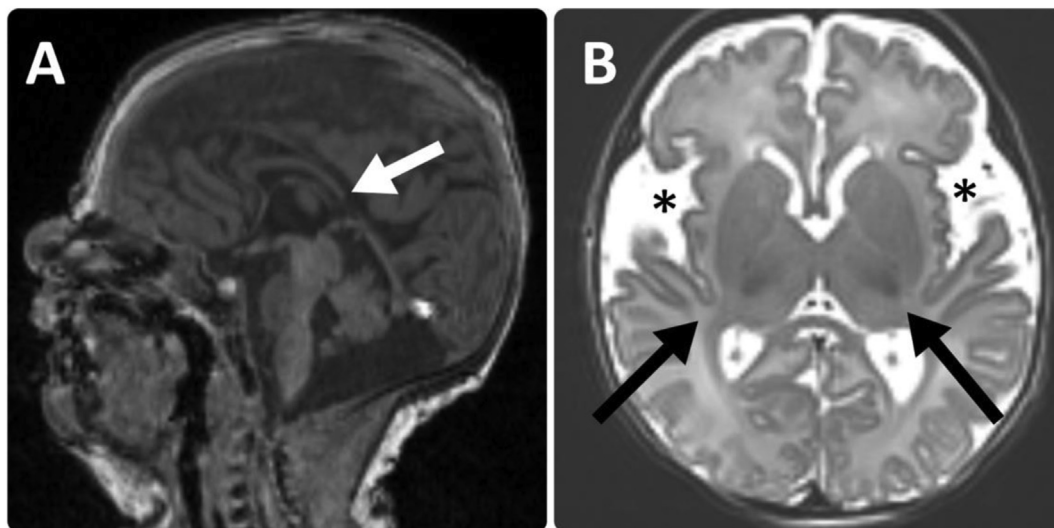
Brain developmental abnormalities in children with moderate to severe hypoxic-ischemic encephalopathy. (A) Sagittal T1-weighted image demonstrates dysgenesis of the corpus callosum, with early termination of the corpus callosum (white arrow) due to absent posterior body and splenium. (B) Axial T2-weighted imaging demonstrates white matter hypoplasia as evidenced by diminished peritrial white matter volume (black arrows) and wide sylvian fissures (black asterisks) in an infant who was born at 40.5 weeks gestational age.
